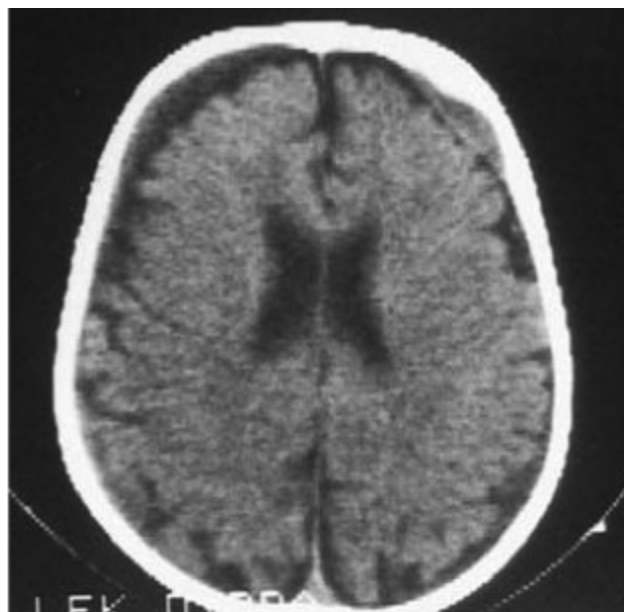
Patient I.M. at the age of 5 months with large fluid collections at the frontal, occipital and parietal region – a; 1,5 month later a marked reduction of fluid collections with contrast enhancement of , what can be interpreted as pericerebral abscesses – b; next CT scan performed eight months later revealed regression of the size of abscesses with residual changes – c; four months later CT revealed fluid collections at frontal and right occipital regions – d.
